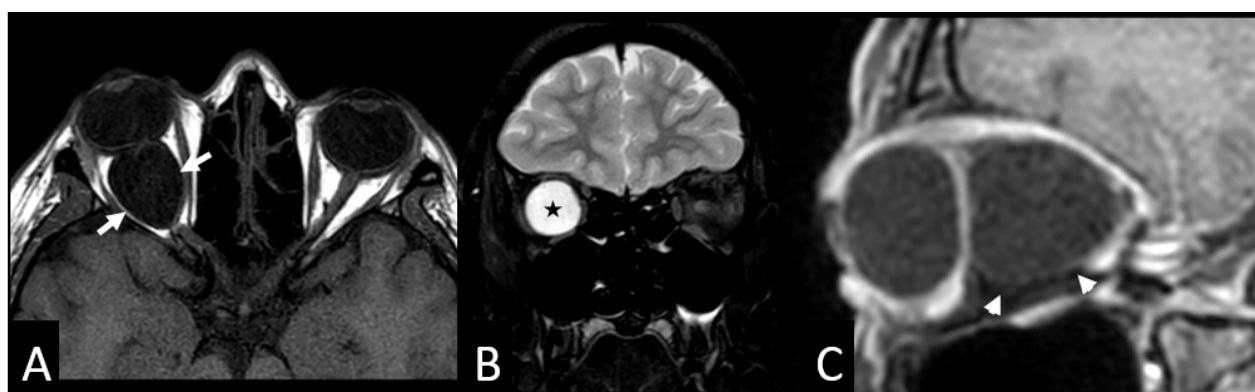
MRI: A) hypointense on T1 WI retroorbital mass with anterior displacement of the globe; B) hyperintense on T2 WI identical signal to cerebrospinal fluid (black star); C) No evidence of enhancement after intravenous contrast injection (white arrowheads)
